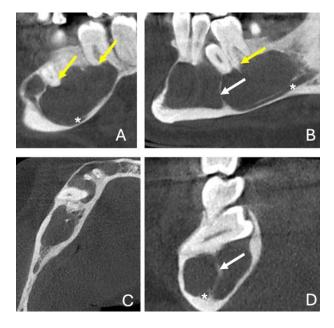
(A, B) Sagittal CBCT images and (C, D) axial CBCT images depicting the septa formation characteristic of ameloblastoma. Yellow arrows indicate root resorption, while white arrows point to the septa formation. The asterisk marks the inferior displacement of the mandibular canal
